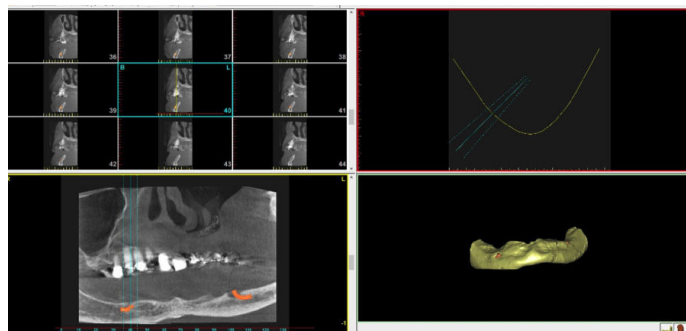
CT Scan/Resorbed Mandible
